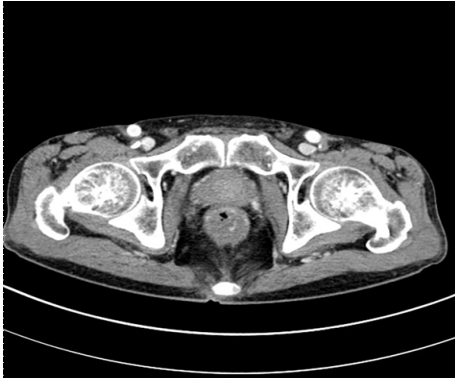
Abdominal and pelvic computed tomography scan showing contrast leakage into the rectum.
